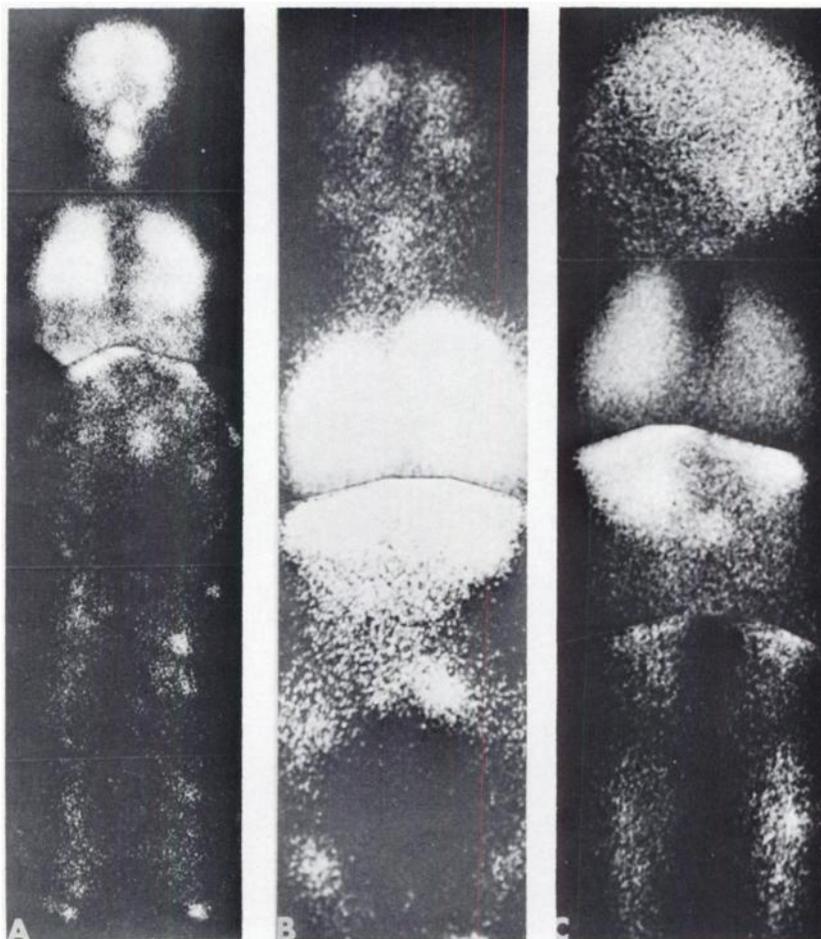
Total-body scintigrams. A shows 6-year-old with 51% right-to-left shunt. B shows 4-month-old with 25% shunt. C shows 2-year-old with 53% shunt. Child's head is turned to right.
